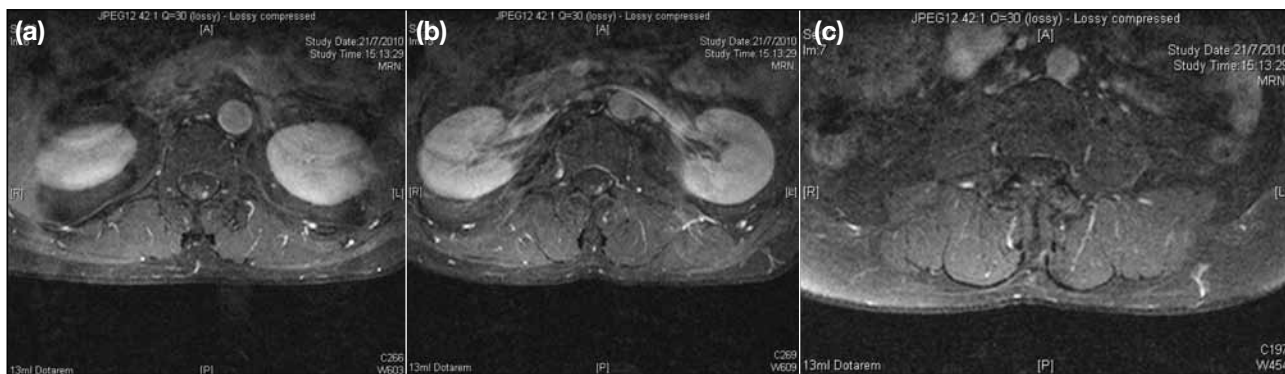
Axial cuts of pre-chemotherapy magnetic resonance imaging (gadolinium-enhanced T1-weighted sequences) showing leptomeningeal nodular enhancement at the levels of (a) T12, (b) L1, and (c) L3.
